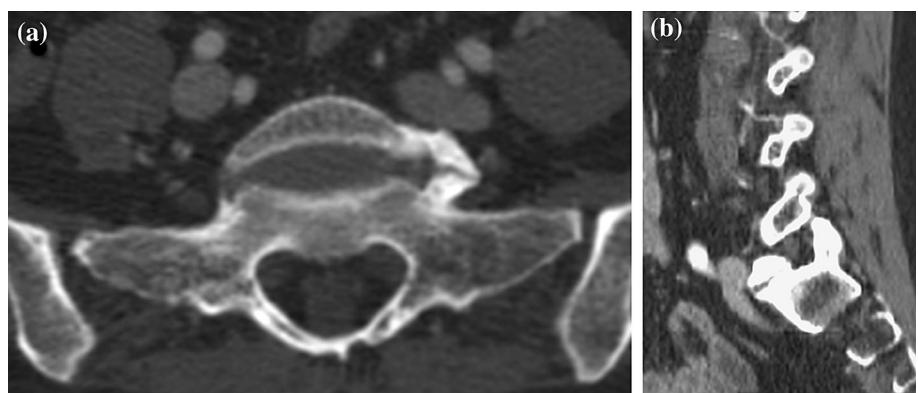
CT scan with 3D reconstruction (a–c) of the lumbosacral junction confirming the large left L5S1 osteophyte
